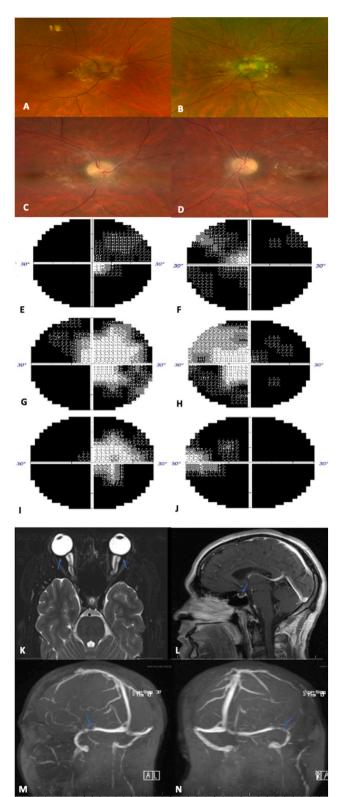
Case 2. (A, B) Optic disc edema, peripapillary exudates, and flame hemorrhage 3 months after onset of vision loss. (C.D) Optic disc pallor 1 year later after IIH treatment. (E, F) Severely constricted visual fields 3 months after onset of vision loss. (G, H) Improved visual fields after bilateral optic nerve sheath fenestrations and acetazolamide therapy. (I, J) Worsened visual fields 1 month later prompting ventriculoperitoneal shunt. (K, L, M, N) MRI and MRV showed prominent cerebrospinal fluid at the optic nerves, empty sella, bilateral focal transverse sinus narrowing, and no evidence of thrombosis.
